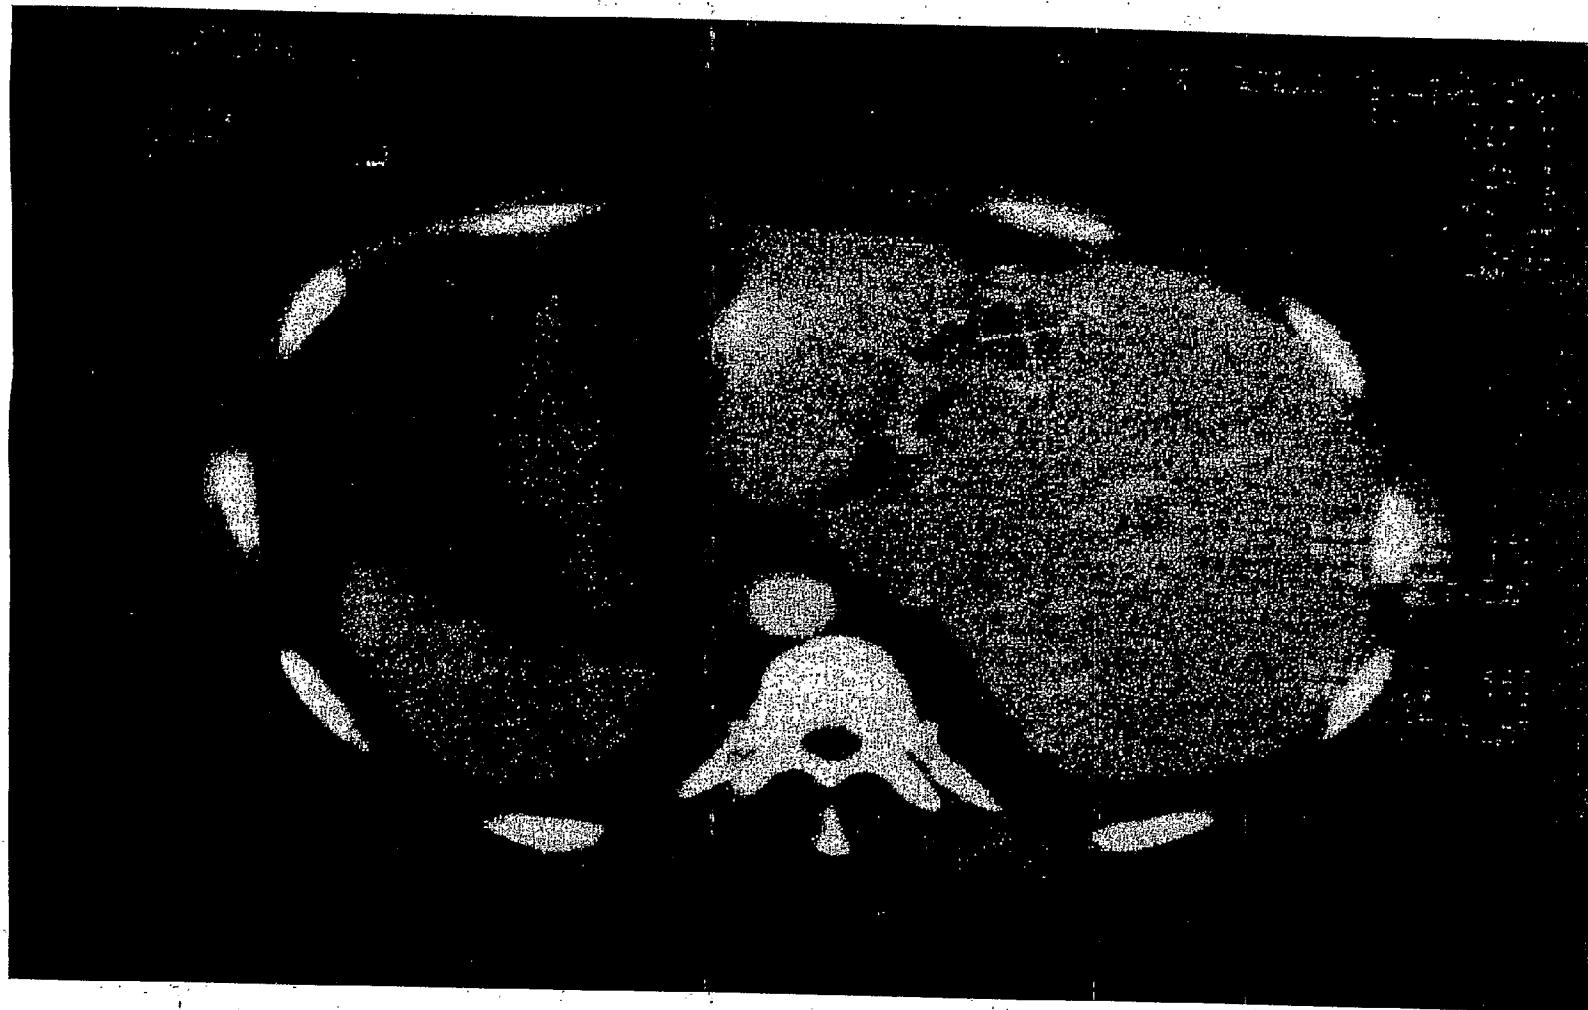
is CT Scan report of patient operated for colorectal cancer with liver metastasis before treatment (38 x38 mm)
